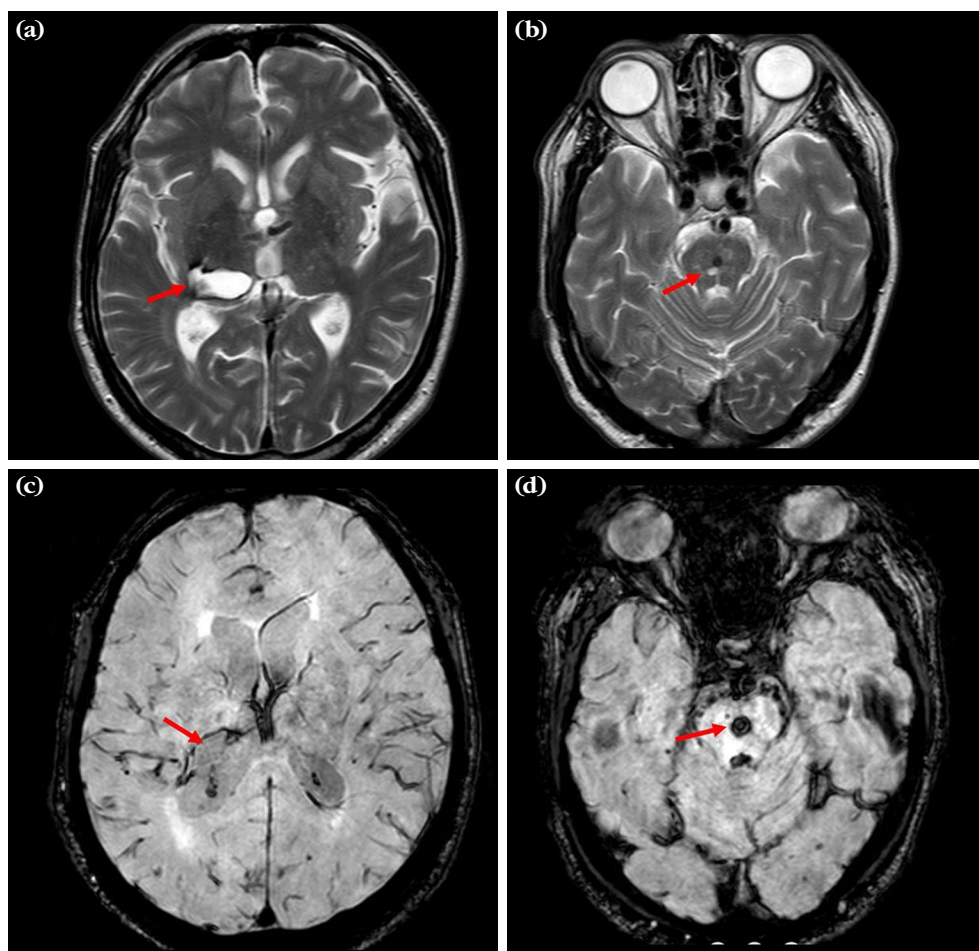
The cranial magnetic resonance imaging sequences showing the sequela lesion of the ischemic stroke in the ventral posterolateral and dorsal portions of the right thalamus (a, c; indicated by arrows on T2-weighted images) and sequela of the pontine hemorrhage (b, d; indicated by arrows on susceptibility-weighted imaging).
